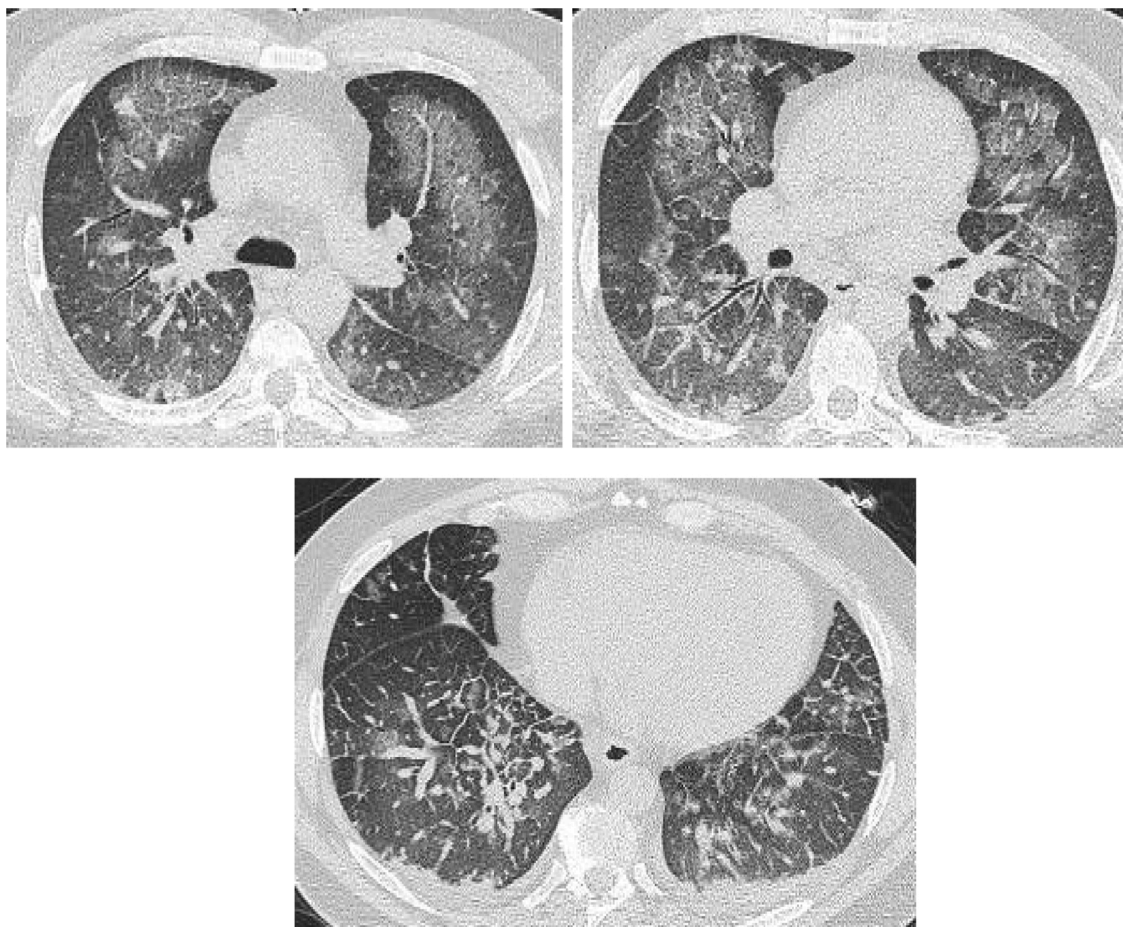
65 yo F with CHF and fluid overload following surgery. CT images demonstrate perihilar ground-glass opacities and thickening of the interlobular septa and bronchovascular bundles.
